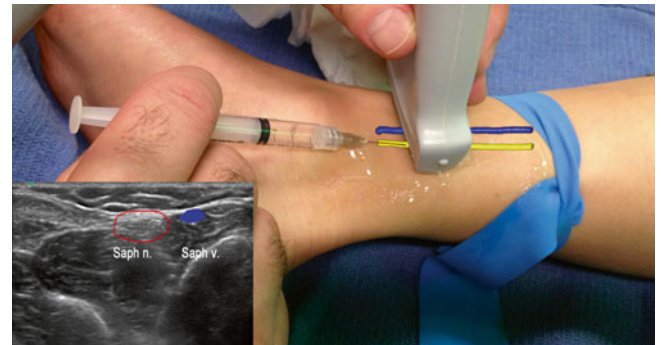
Out-of-plane ultrasound injection of the distal saphenous nerve. Note the tourniquet to increase the size of the saphenous vein for easier localization (Image courtesy of Michael Brown, MD)
